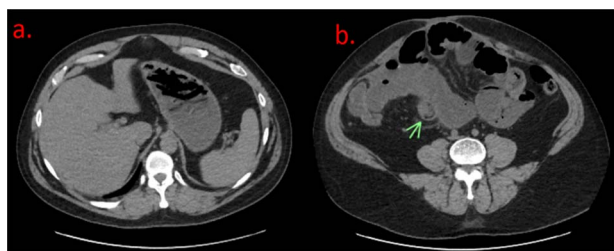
(a) Axial noncontrast CT of the abdomen demonstrating a nondescript, fluid-filled stomach. (b) Axial noncontrast CT reveals dilated loops of small bowel with classic “bowel within bowel” appearance of the small intestine, labeled with an arrow. This was thought to be the lead point for the suspected SBO.
